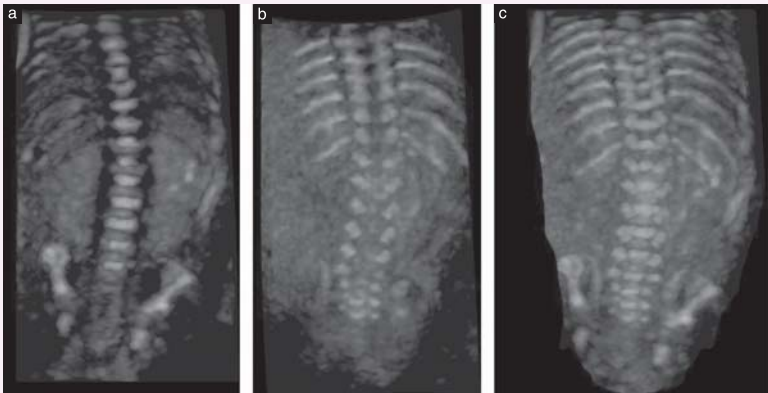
Three-dimensional (3D) surface-rendering of fetal spine at 22 gestational weeks: coronal views. These images were obtained with 3D ultrasound from same sonographic volume, using different angulations and thicknesses of ultrasound beam: (a) thin beam oriented through bodies of vertebrae; (b) same beam oriented more posteriorly to demonstrate posterior arches of vertebrae; (c) thick ultrasound beam used to demonstrate simultaneously all three ossification centers.
